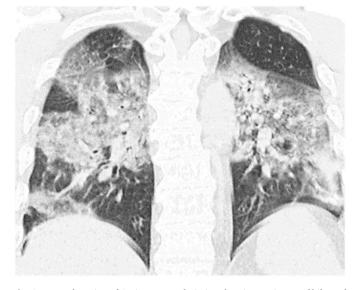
Frontal section of CT-image on admission showing a mixture of bilateral ground glass attenuation and consolidations. In retrospect, the highly convex diaphragm contours may have been an indication of poor function.
